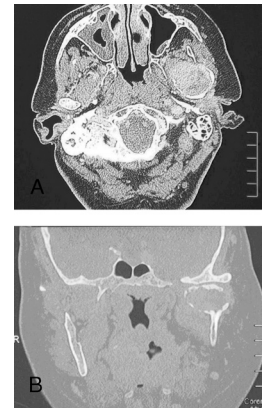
A, Axial CT image of the left mandibular condyle. B, Coronal CT image of the left mandibular condyle.
